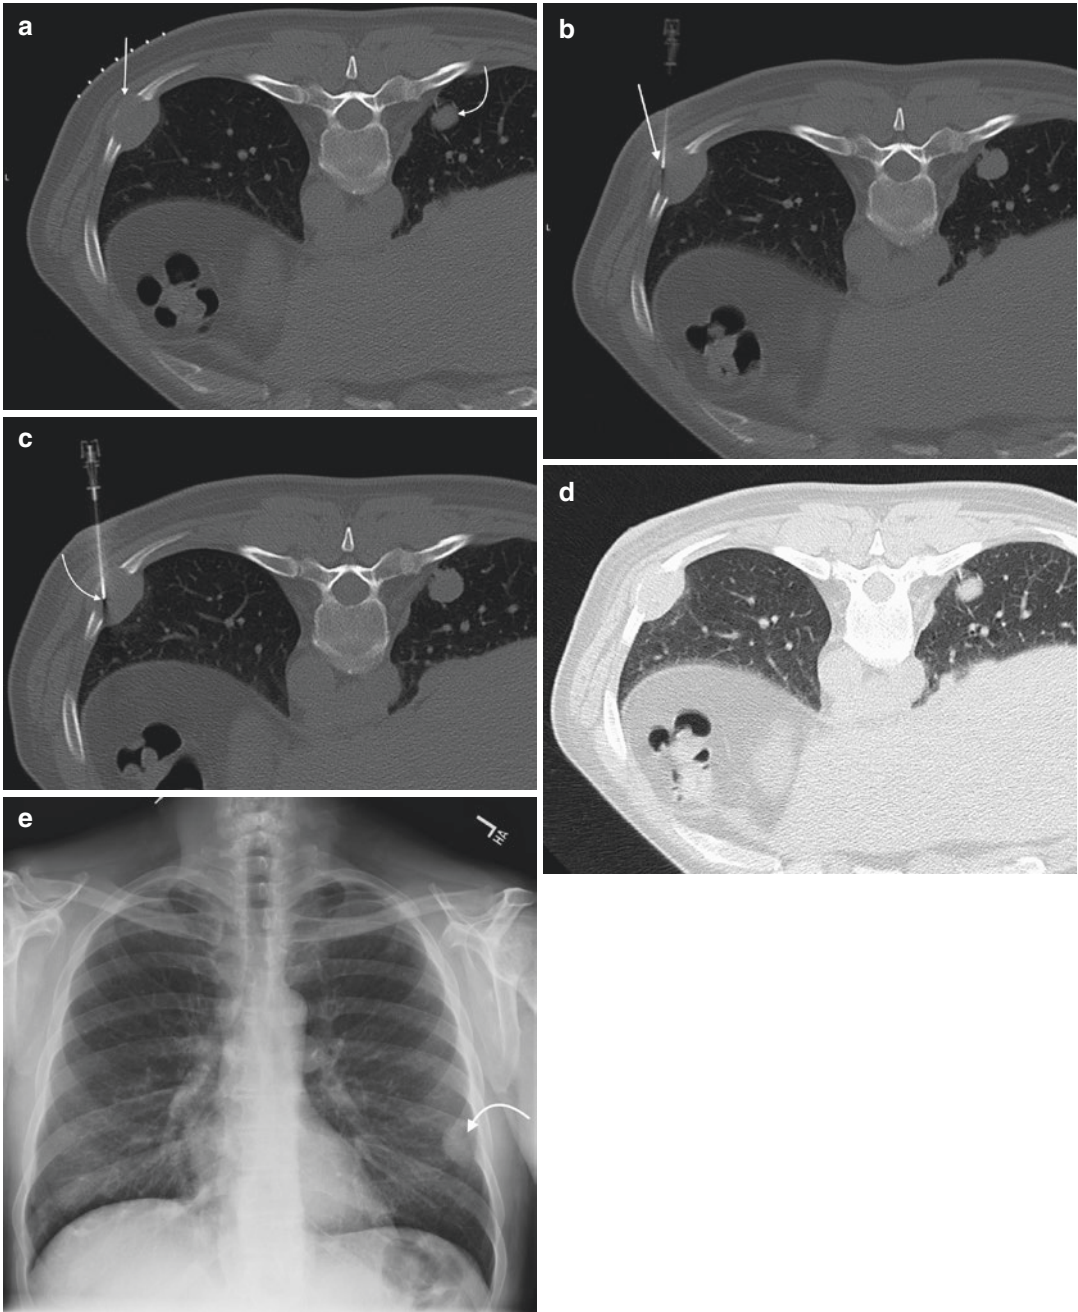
A 53-year-old male with multiple pulmonary nodules and a rib lesion seen on a chest CT. Axial CT image (a) with a skin grid in place, and patient in prone position, shows a large expansile soft tissue mass within the left posterior ninth rib (*arrow*). Note the pulmonary mass (*curved arrow*). Since this lesion is located within the lateral aspect of the posterior rib, a lateral and downward needle trajectory is used to sample the lesion with this posterior approach (*arrow*). Axial CT image (b) shows placement of a 19-gauge guide needle at the margin
